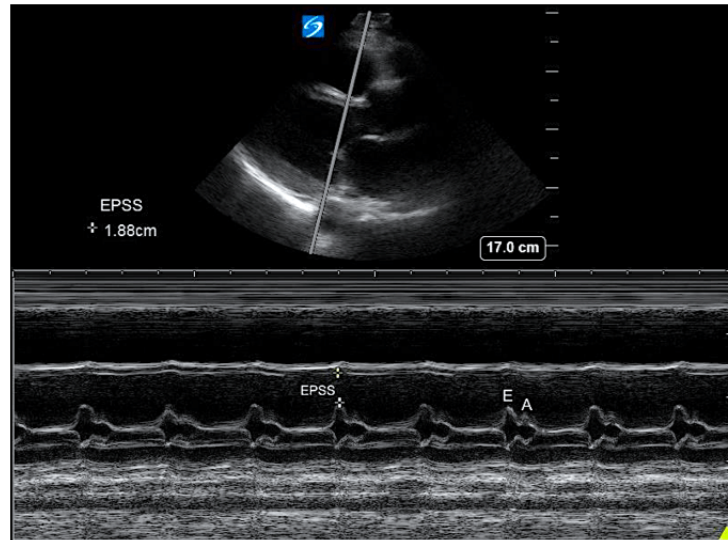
Example of M-Mode ultrasonogram. [17]
